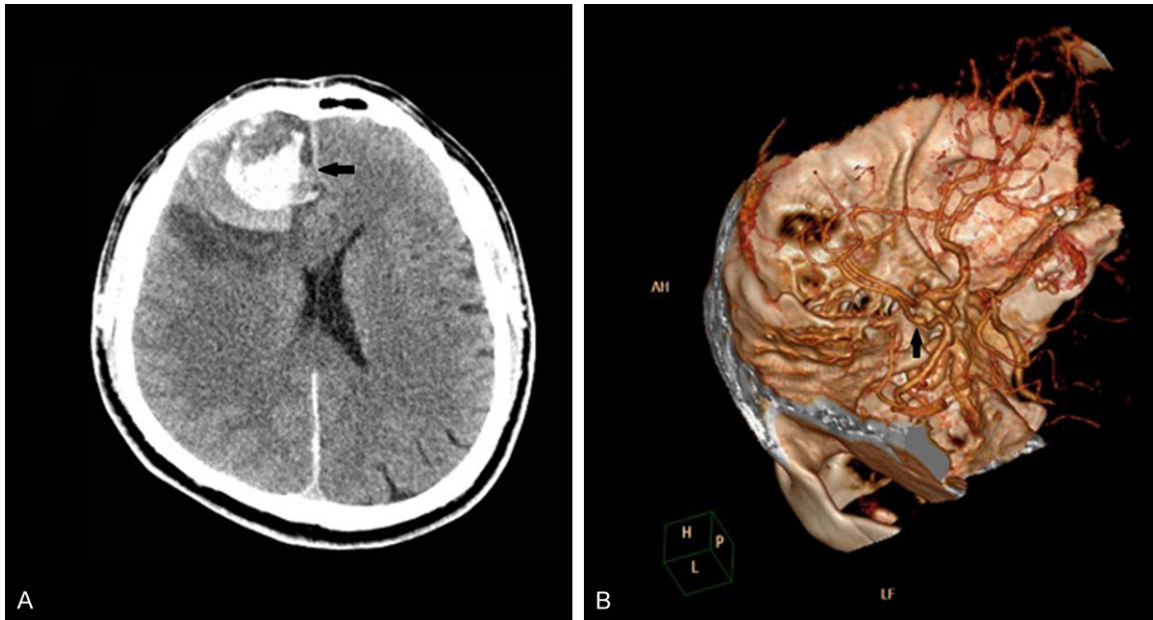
CT scan and computed tomographic angiography (CTA) on admission. CT scan showed a right-sided frontal hybrid density mass lesion (arrow) with perifocal edema, swelling of the brain, slight compression of the right lateral ventricle and subarachnoid hemorrhage (A). CTA revealed a small projection (arrow) on the A1 segment of the left anterior cerebral artery (ACA) (B).
